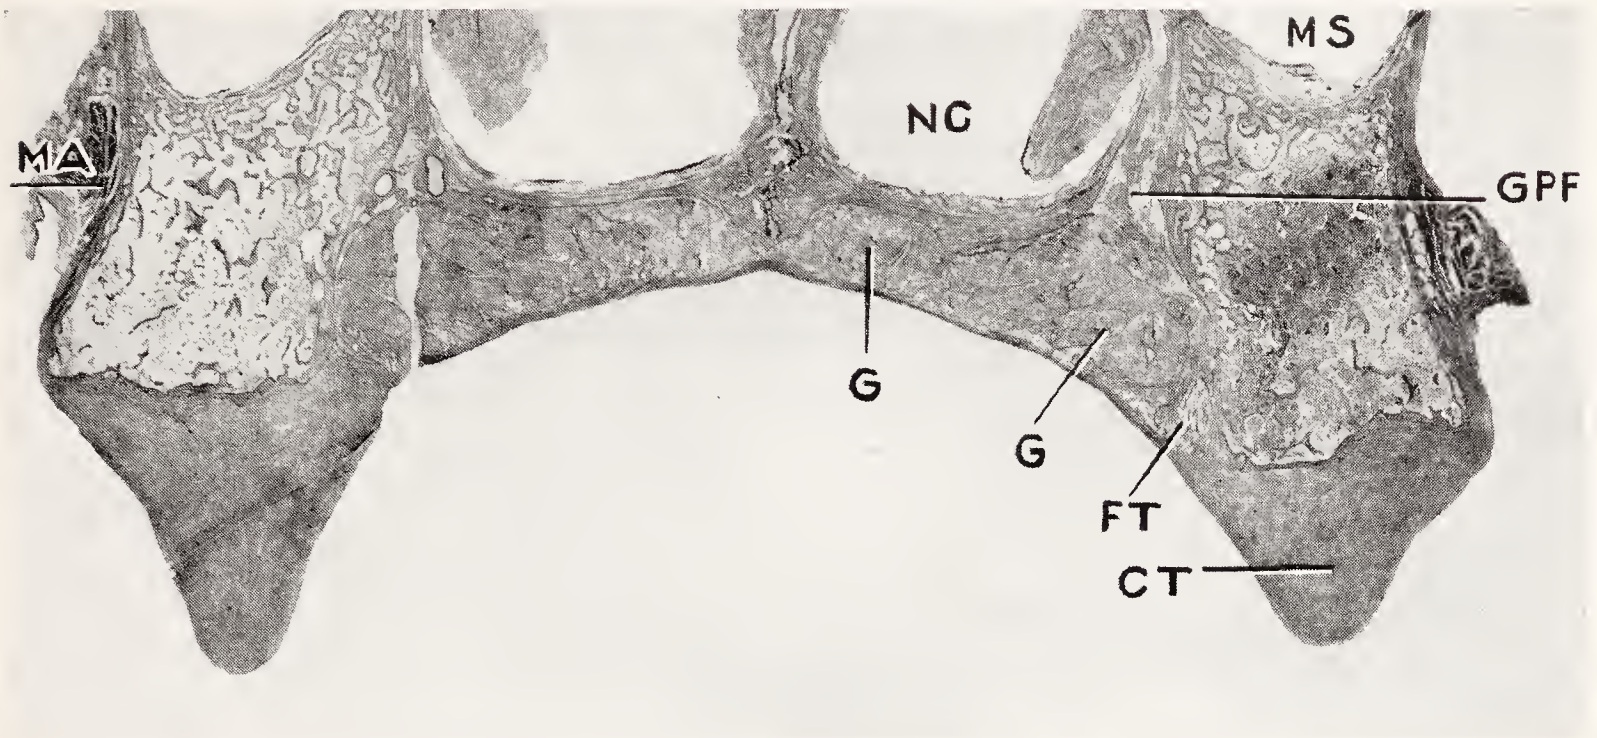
Frontal section through an edentulous maxilla in the region of the upper third molar. *NC*, nasal cavity; *MS*, maxillary sinus; *GPF*, greater palatine foramen; *CT*, fibrous connective tissue on crest of ridge; *FT*, fat tissue; *G*, glands of palate; *MA*, buccal muscle attachment (buccinator muscle). (Pendleton, Jour. Am. Dent. Assn.)
